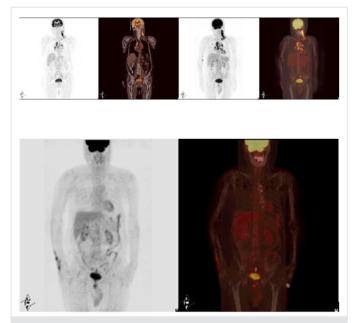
A) Top row: Initial (pre-treatment) FDG-PET/CT, B) Bottom row: Post-treatment FDG-PET/CT. Maximum intensity projection images of a patient with a mixed cell type of HD, who had unfavorable pre-treatment risk scoring. All hypermetabolic foci seen on the initial PET/ CT study completely disappeared in the post-treatment study done after completion of chemotherapy. The patient stayed in remission during 29 months follow-up period
